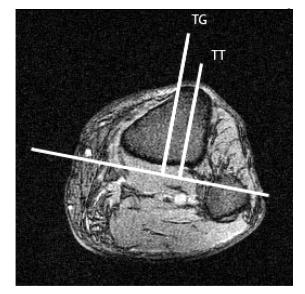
MRI showing trochlear groove with transverse condylar line and perpendicular line through trochlear groove.
